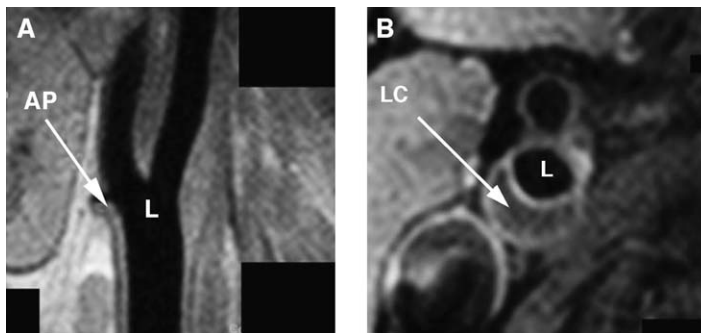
High-resolution MR images of the right carotid artery of another patient with advanced atherosclerosis. (A) Oblique proton density image through the proximal internal and external carotid arteries. This image was used to prescribe subsequent images. AP, atherosclerotic plaque; L, lumen. (B) T1-weighted postcontrast FSE image of the right internal carotid artery demonstrating significant arterial wall remodeling caused by atherosclerotic plaque with an excellent postcontrast delineation of the lipid core (LC). L, lumen.
